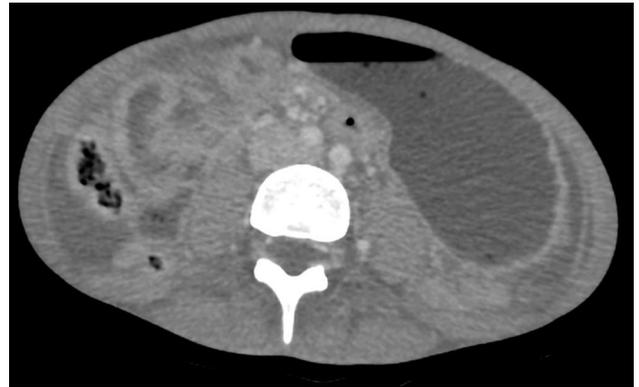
Figure Computed tomographic image demonstrating ascites with abnormal peritoneal enhancement without evidence of intestinal perforation.
